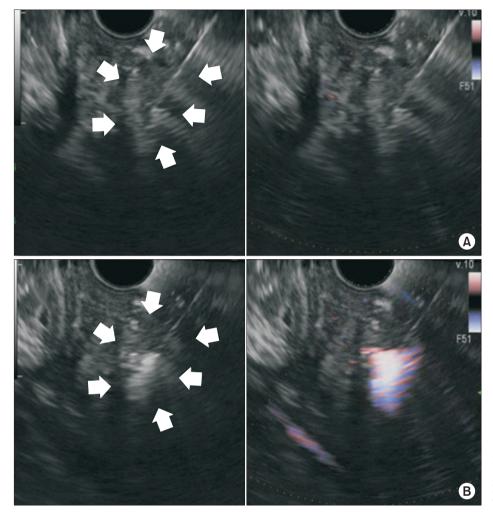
Endoscopic ultrasound and Doppler flow images. (A) The tip of EUSRA needle was placed into the pancreatic neuroendocrine neoplasm (arrows) in head, (B) echogenic cloud around the needle during radiofrequency ablation (19 gauge EUSRA with 10 mm electrode, power 30 W, duration 15 seconds) (arrows).
